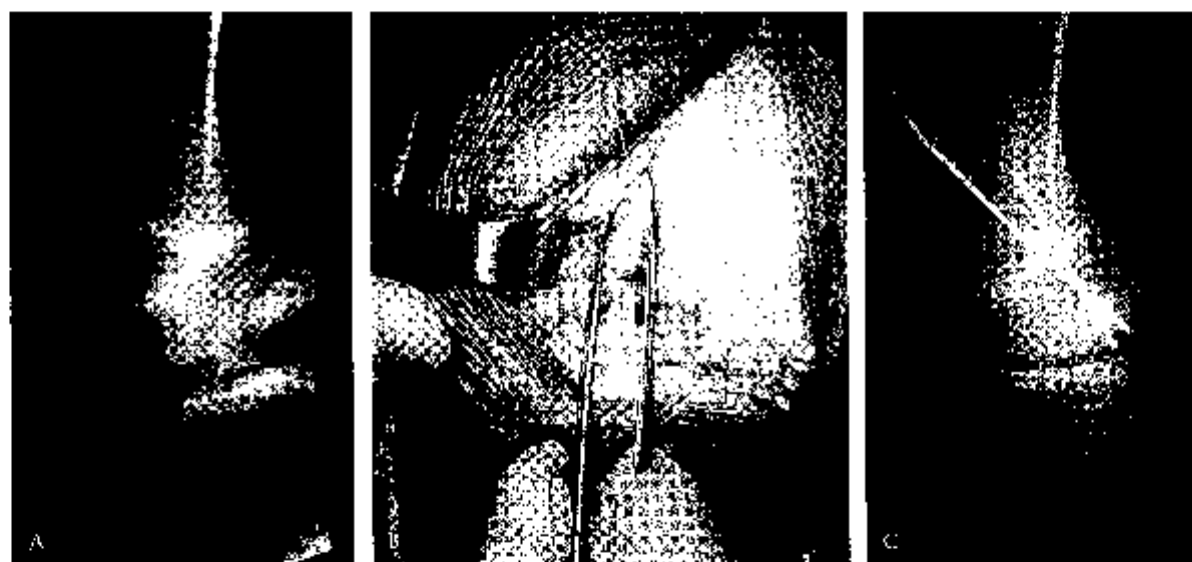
Unstable OCD lesion in a patient approaching skeletal maturity (A) treated with arthrotomy (B), bone grafting, and K wire fixation (C) 3 months postoperative radiograph.
